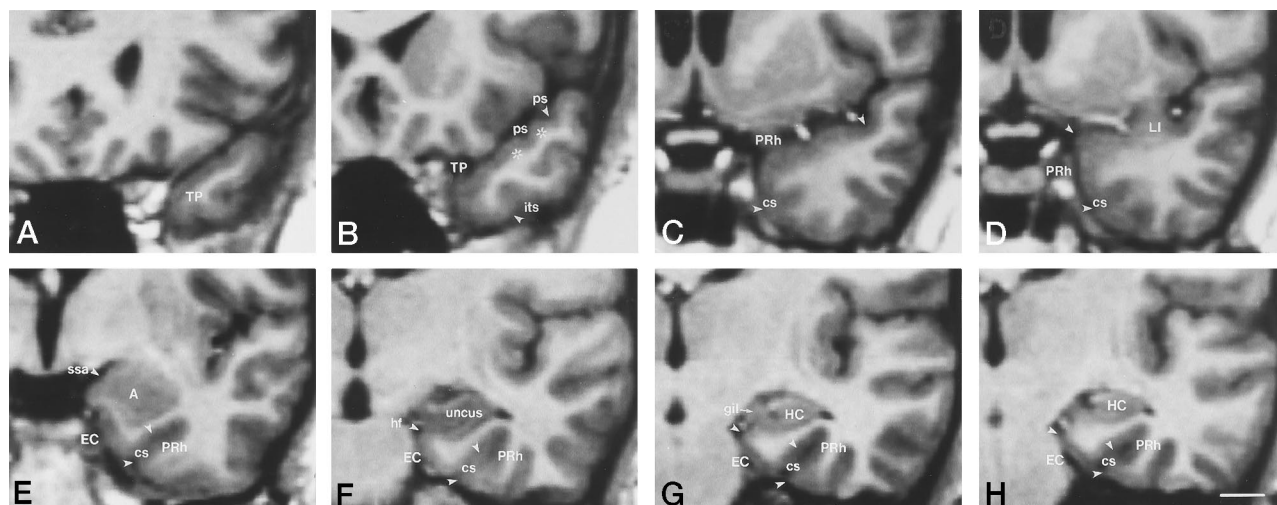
Major anatomic landmarks used to identify the temporopolar, perirhinal, and entorhinal cortical boundaries (indicated with arrowheads) in coronal MR images. A is the most rostral and H is the most caudal.
